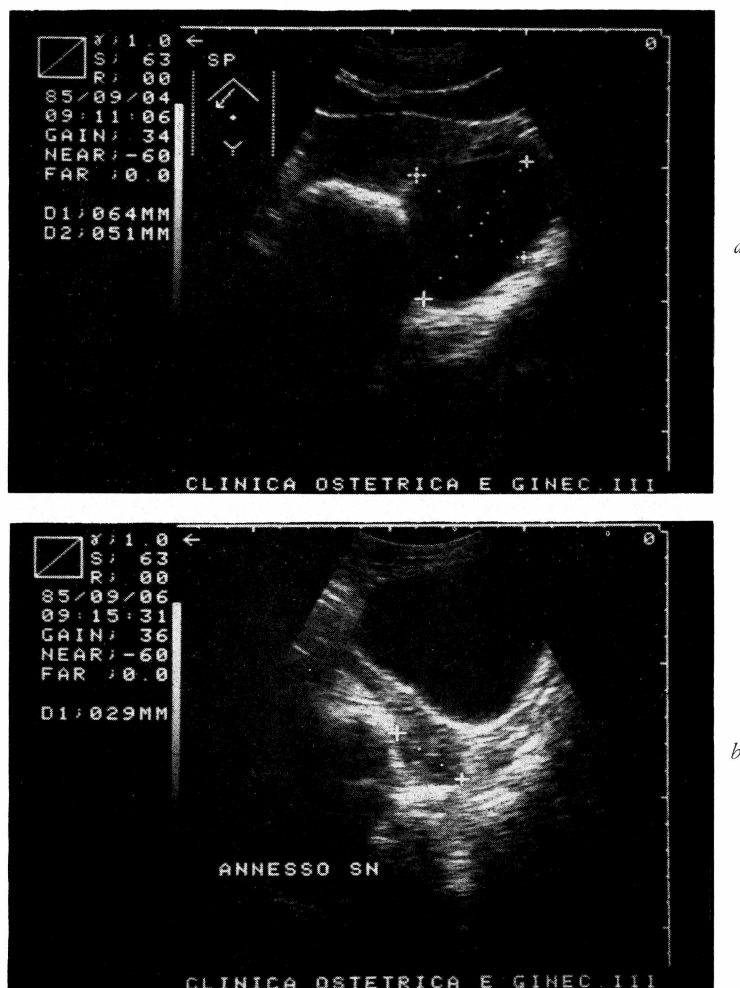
Transabdominal ultrasonography before (a) and after (b) ultrasound guided aspiration.
